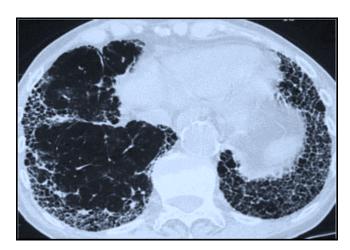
CT findings suggestive of UIP pattern in IPF
